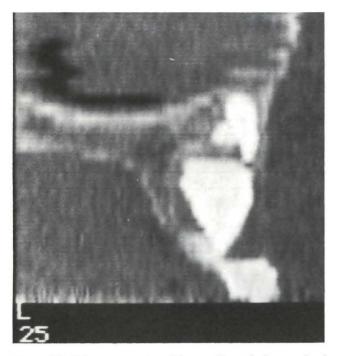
CT reconstruction of the maxilla at the buccopalatal plane shows that tooth #21 has only a crown and no root. Palatal to the crown there is another round tooth-like structure. The crown is adjacent to, but separated from the nasal cavity and close to the buccal bone plate, allowing safe surgery from a buccal approach.
